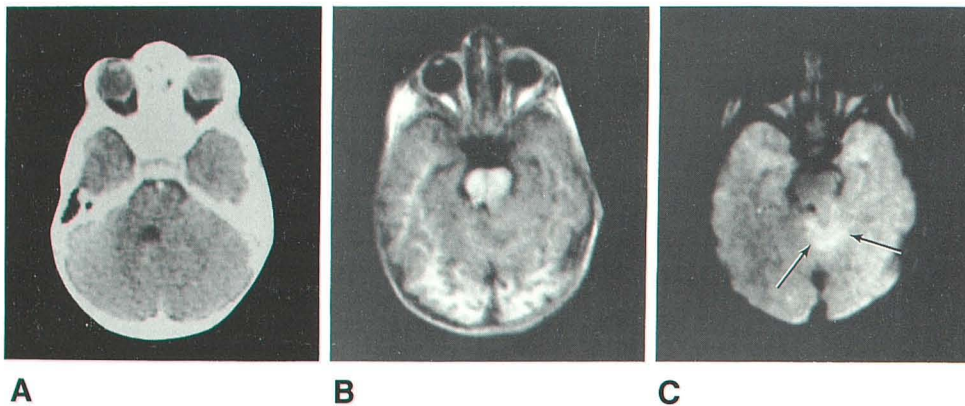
Hamartoma. Contrast-enhanced CT (A), IR 1800/600 (B), and SE 1580/80 (C) scans. Displacement of fourth ventricle to left is seen on CT (A). Lesion with T1 similar to that of gray matter and increased T2 (*arrows*) is demonstrated on MRI (B and C).
